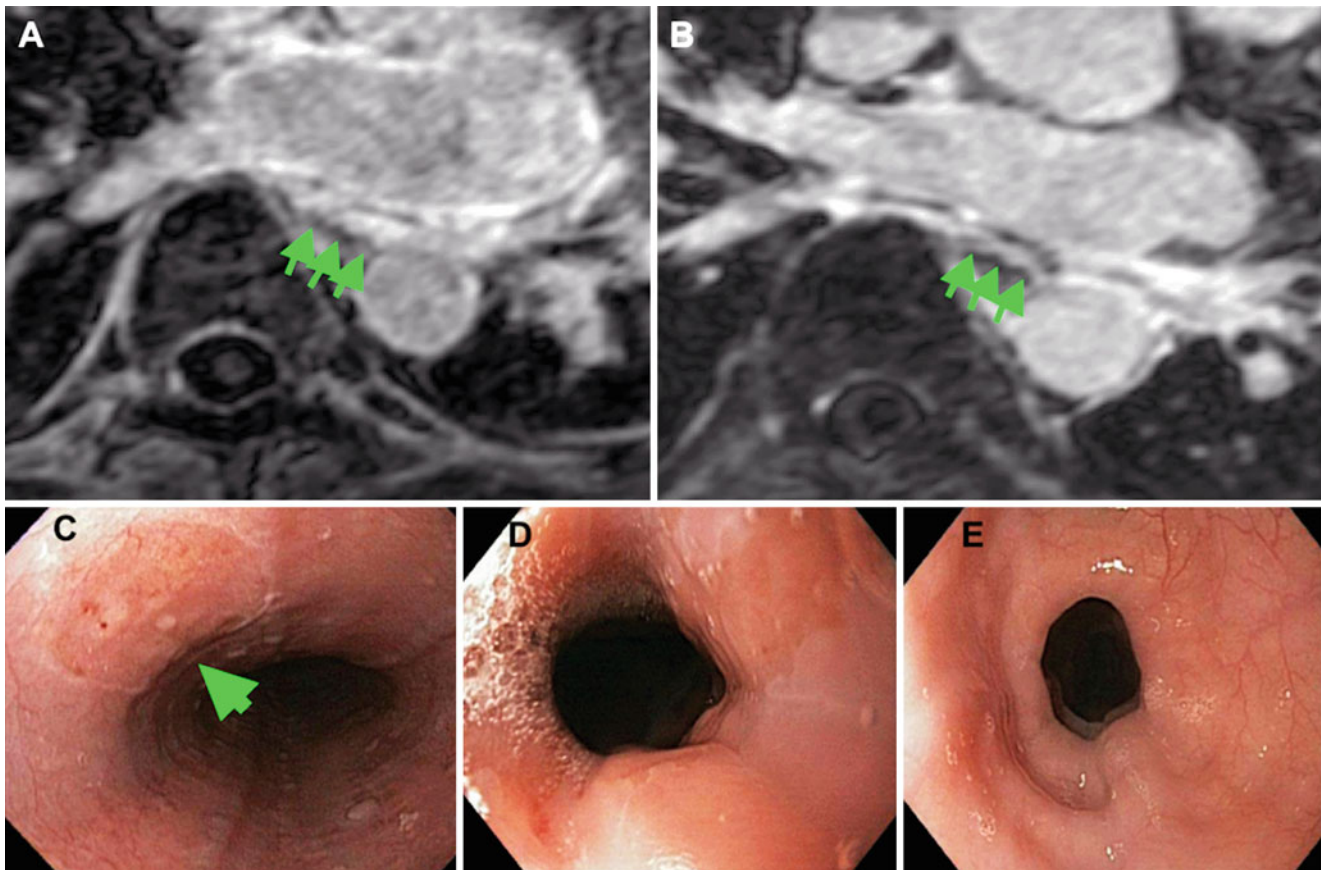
LGE-MRI of the esophagus and EGD. (a) LGE-MRI demonstrates enhancement of the anterior esophageal wall (arrows) which correlates with a lesion (green arrow) found on EGD (c). (b) A week
